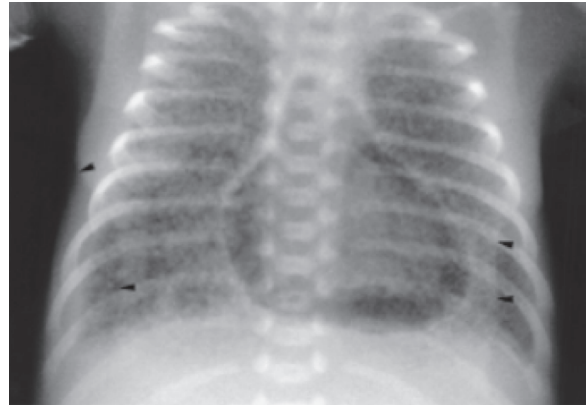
Neonatal pneumomediastinum. Note the thymus gland outlined by air, giving an “angel’s wing” appearance (arrow heads). (From Arthur R: The neonatal chest x-ray. *Paediatr Respir Rev* 2:311, 2001.)
